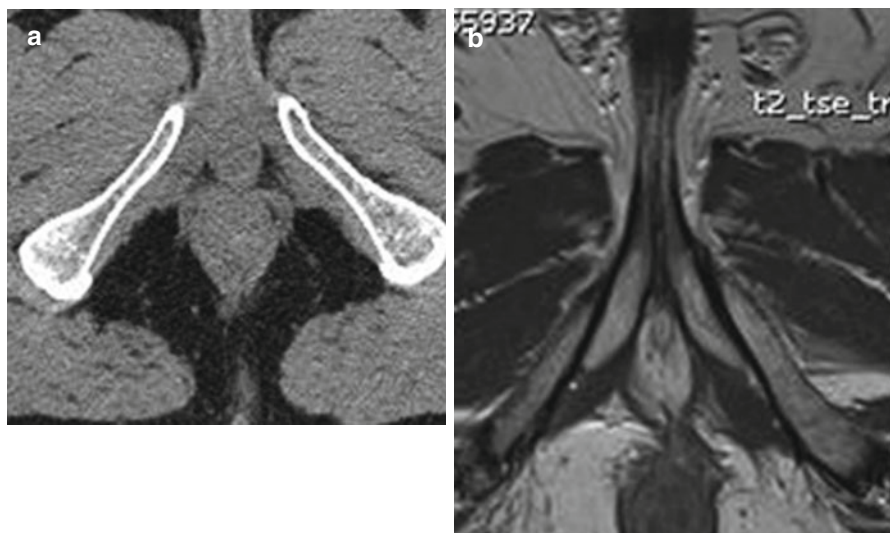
Axial CT (a) and MRI (b) through penile bulb
